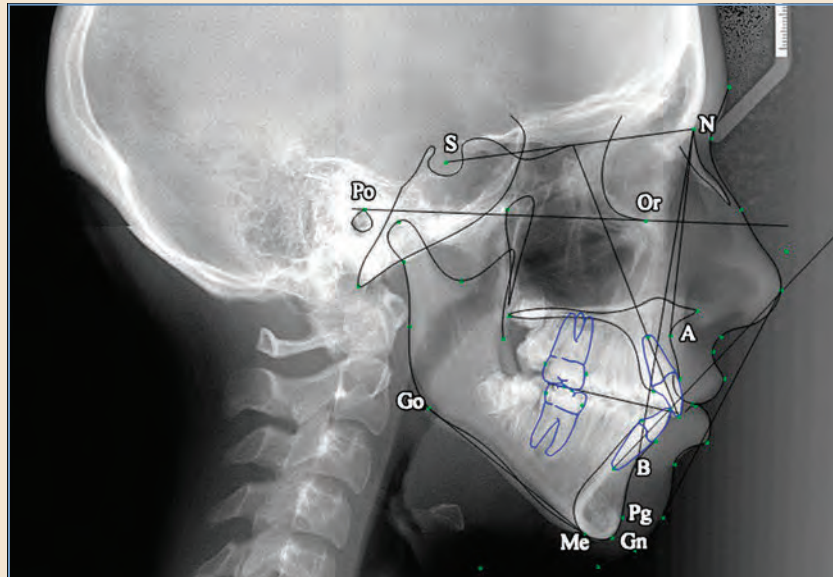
Lateral cephalometric radiograph with common landmarks. (*A*, A point: innermost point in the depth of the concavity of the maxillary alveolar process. *B*, B point: innermost point on the contour of the mandible between the incisor tooth and the bony chin. *Gn*, gnathion: center of the inferior contour of the chin. *Go*, gonion: most inferior and posterior point at the angle, it is formed by the ramus and body of the mandible. *Me*, menton: most inferior point on the mandibular symphysis. *N*, nasion: anterior point of the intersection between the nasal and frontal bones. *Or*, orbitale: lowest point on the inferior margin of the orbit. *Pg*, pogonion: most anterior point on the contour of the chin. *Po*, porion: uppermost lateral point on the roof of the external auditory meatus. *S*, sella turcica [midpoint of the sella turcica].)
